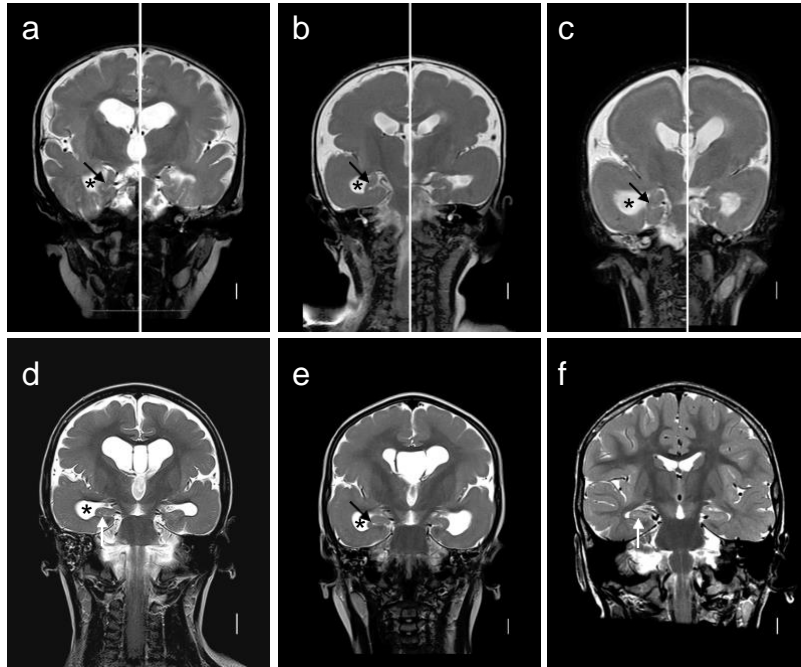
Brain imaging in *APC2*-lissencephaly in 5 children highlighting hippocampal malformations. Subjects 5-II-1 (a), 6-III-1 (b), 6-III-2 (c), 7-III-3 (d), 7-III-4 (e), and a normal control (f). The T2-weighted coronal images through the posterior frontal lobes and hippocampi showed globular and open hippocampi (a-c, e) that were usually under developed (a-c). The hippocampi in one child appear normal on these images (d), but all five subjects have moderately enlarged temporal horns (asterisks in a-e), which is commonly seen with hippocampal malformations associated with lissencephaly. All images are T2-weighted.
